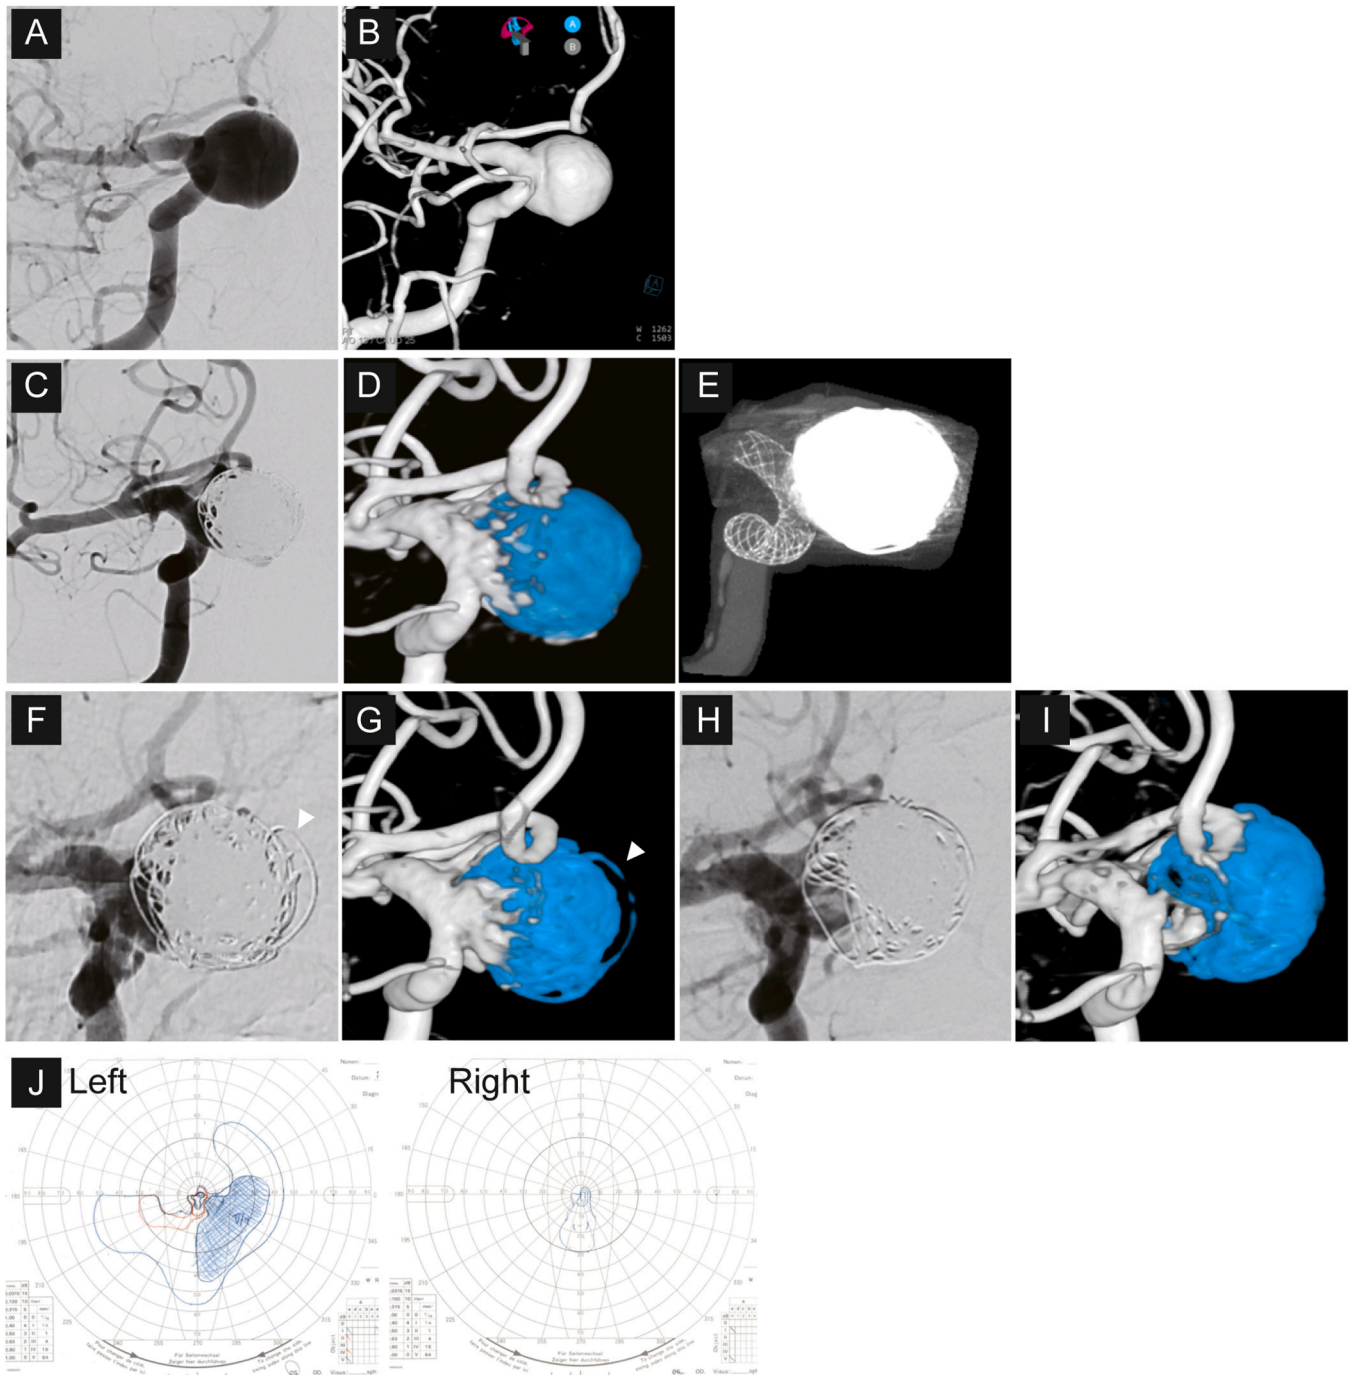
Images before and after coil embolization and flow diverter placement. A. An angiographic image of the aneurysm before endovascular surgery. B. A 3D-reconstructed image of the aneurysm. C. An angiographic image of the aneurysm after coil embolization. D. A cone-beam computed tomographic image after coil embolization and flow diverter placement. E. A 3D-reconstructed image. Blue indicates the embolized coil. Time course for the change in the shape of treated aneurysm. F-I. Angiographic (F and H) and 3D reconstructed (G and I) images of the aneurysm after endovascular surgery. Blue indicates the embolized coil. F and G: 3 months after endovascular surgery when the symptoms from hydrocephalus were the most severe. The arrowheads indicate a coil loop in the tip of the aneurysm, H and I: 1 year after endovascular surgery. J. The results of the Goldmann visual field test. The test was performed 2 months after endovascular surgery.
